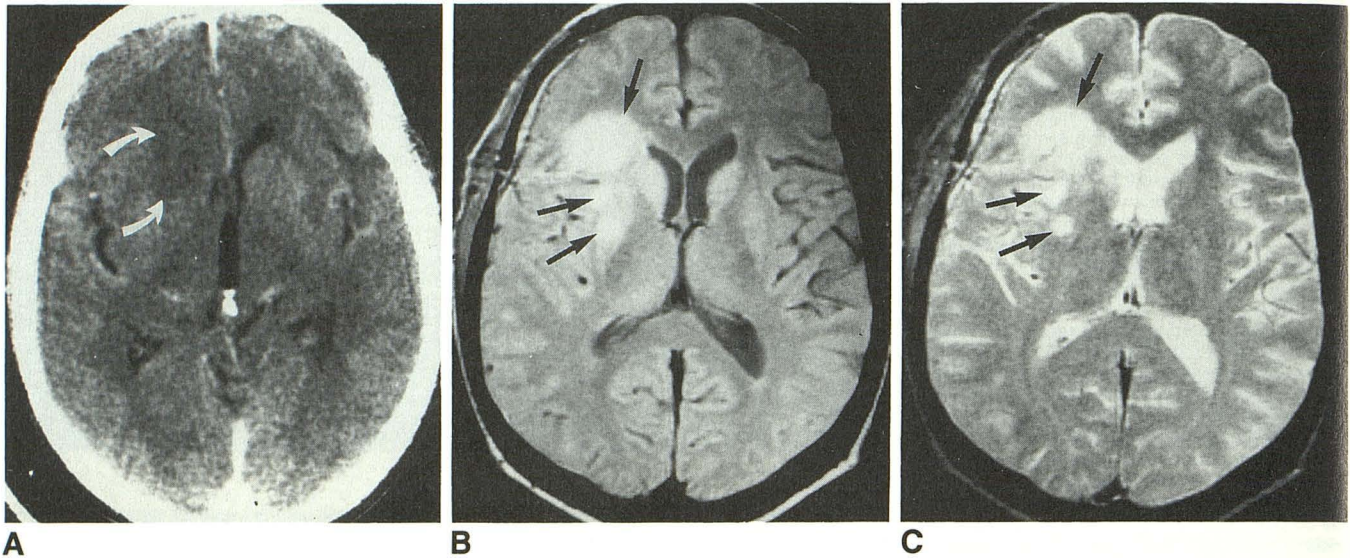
Case 24: 35-year-old man admitted with mental status changes. This is a biopsy proved case of toxoplasmosis. A, Contrast-enhanced CT scan shows ill-defined nonenhancing mass (arrows) in right frontal lobe with compression of adjacent frontal horn. B and C, Proton-density (B) and T2-weighted (C) (2000/80) show three cerebral abscesses (arrows) not evident on CT scan. Notice postcraniotomy changes and slight amount of epidural fluid on the right side.
